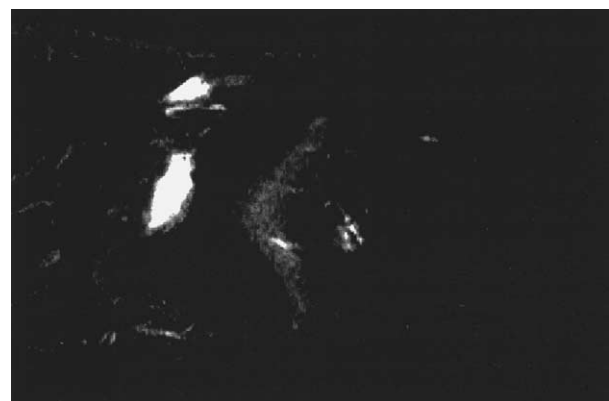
MRI scan showing region of hypertonic saline infiltration in the infrapatellar fat pad.
